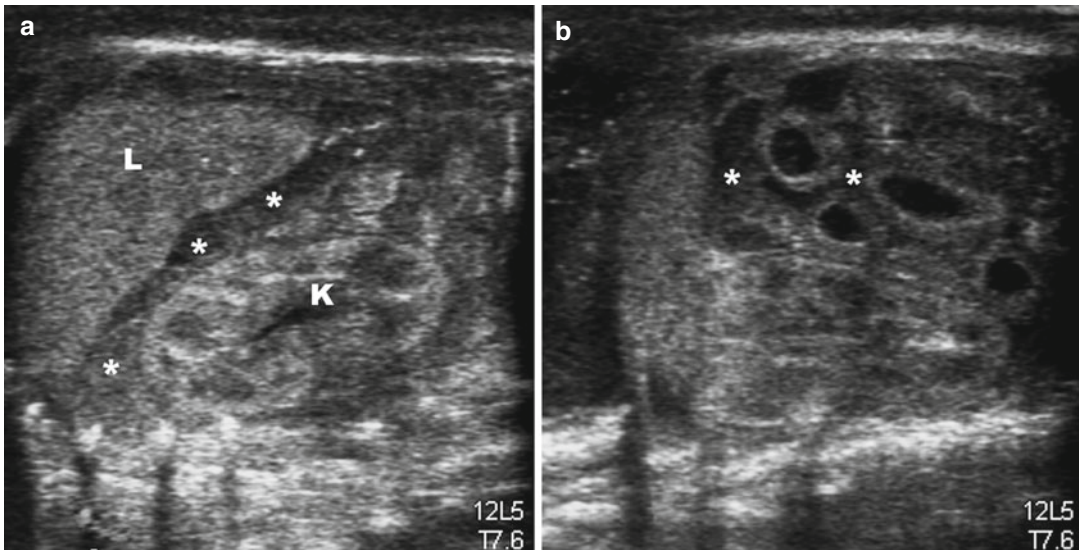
Ultrasound in newborn with NEC. In picture a and b note the inhomogeneous fluid plenty of echoes and contextual septa; this is suggestive for perforation. *L* liver, *K* left kidney, *asterisk* = fluid
